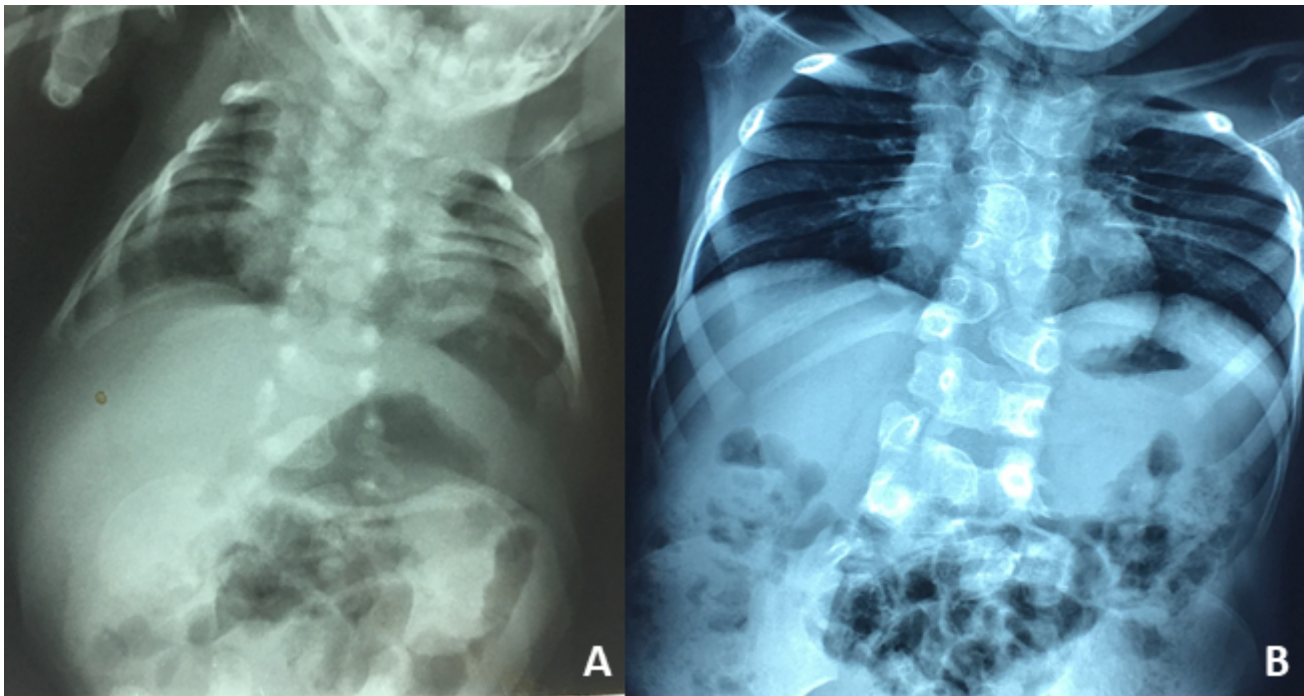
Radiographs of a child with *LFNG*-related SCDO
